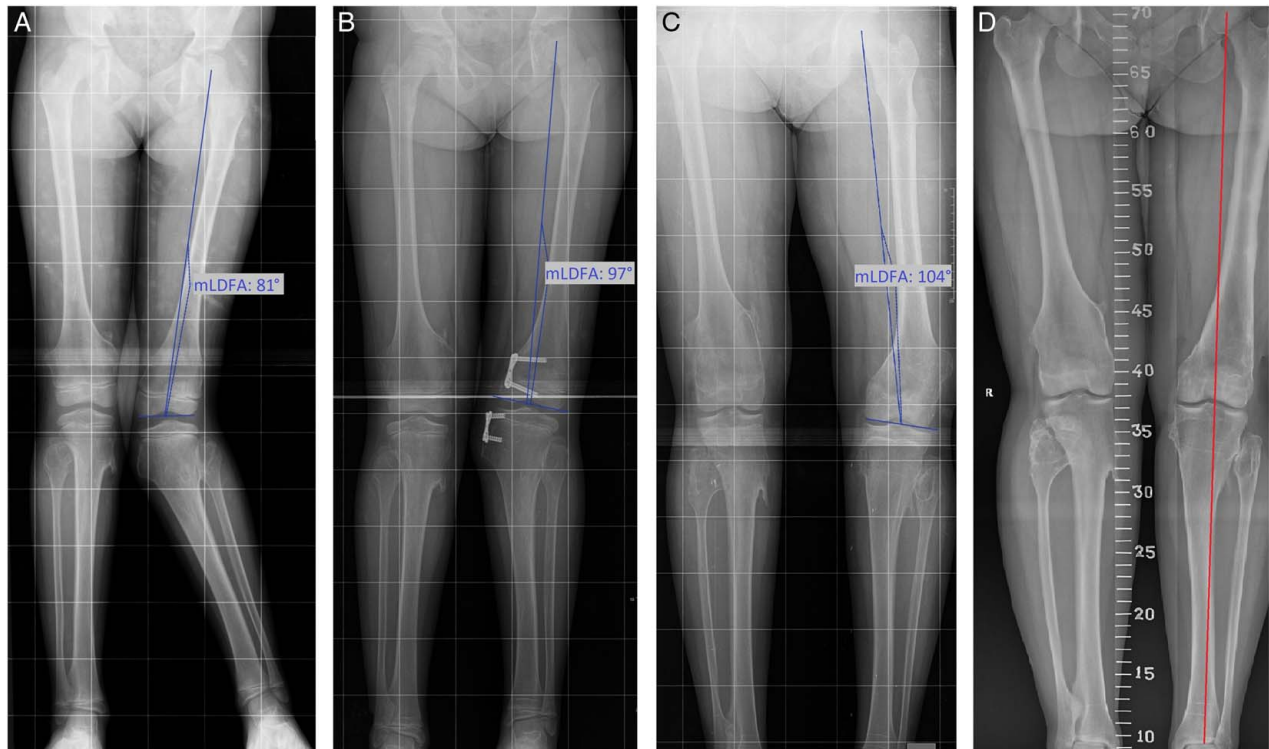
A, Preoperative weight-bearing x-ray of a 7-year-old girl with multiple hereditary exostoses; B, One year after initial surgery, at the implant removal; C, 3 years after implant removal, indicating 7 degrees of continuity of deformity correction in the varus direction; note that this deformity was caused by the exostosis in the lateral distal femur rather than tethering in medial physis; D, Final follow-up shows neutral axis in left lower extremity after multiplanar deformity correction with osteotomy and hexapodal external fixation (This image was given for last follow-up was not included in our data analysis due to the additional surgery performed). mLDFA indicates mechanical lateral distal femoral angles.
